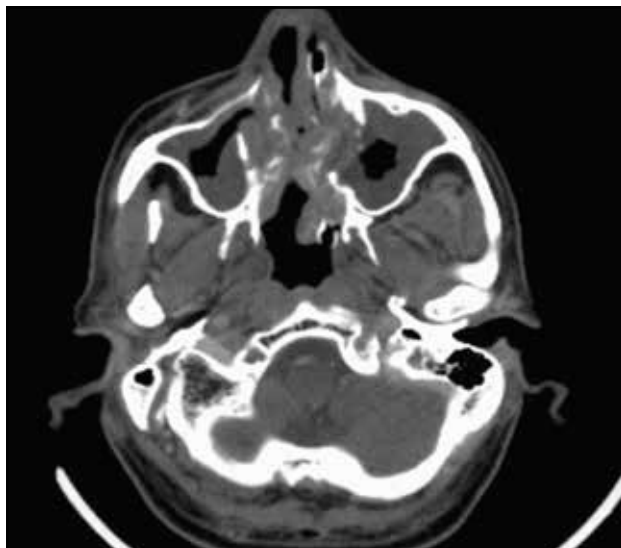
Crano-facial CT scan, axial cut of Case 1 showing a mass in the right maxilla and hard palate.
